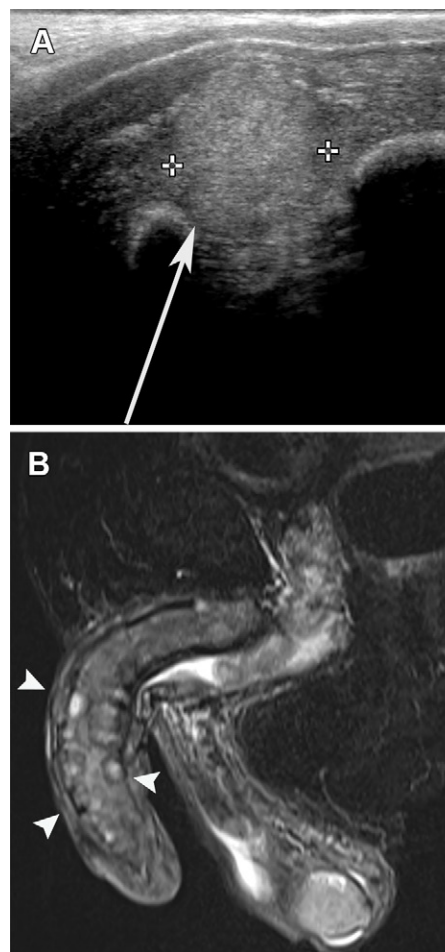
Metastatic mucinous adenocarcinoma of the urinary bladder in a 69-year-old man who presented with painless penile lumps of few months' duration. (A) Longitudinal US image shows an echogenic well-defined nodule within the corpus cavernosum (arrow). Several other mixed echogenic lesions were also demonstrated (not shown), some with mass effect on the tunica. (B) Coronal short-tau inversion-recovery MR image shows multiple mixed-signal-intensity metastases (arrowheads).
